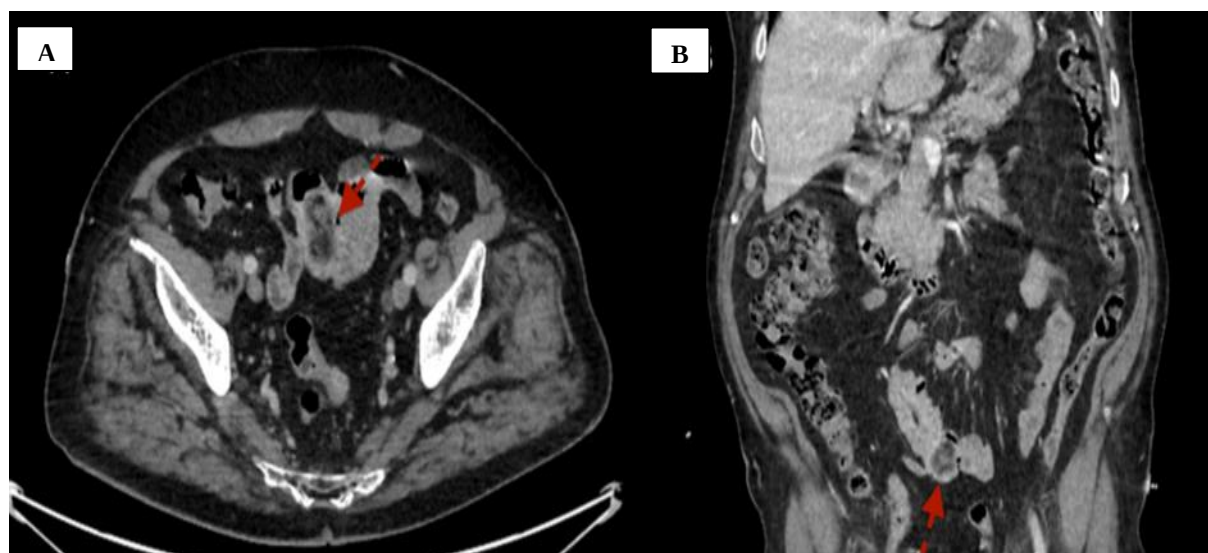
CT Identification of the Jejunal lipoma serving as the lead point of intussusception. (A) Axial CT image showing a well-circumscribed intraluminal fat-density lesion (arrow), consistent with a jejunal lipoma and (B) coronal reconstruction confirming homogeneous fat attenuation and smooth margins (arrow).
